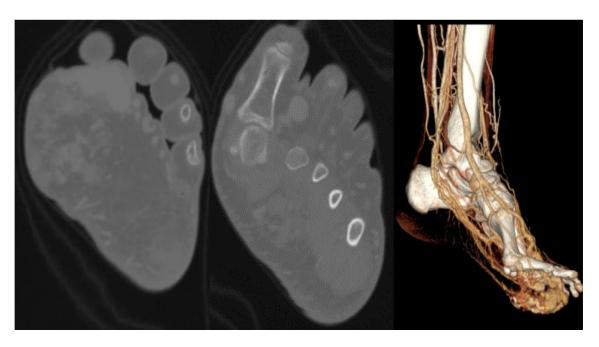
Enhanced computed tomography scan with volume rendering. The medial planter and dorsal pedis arteries, thickened and tortuous, shunting randomly with surrounding veins. The draining veins were visualized earlier through the nidus, as abnormal wiry vessels, and as venous sacs around the first and second proximal phalangeal area.
